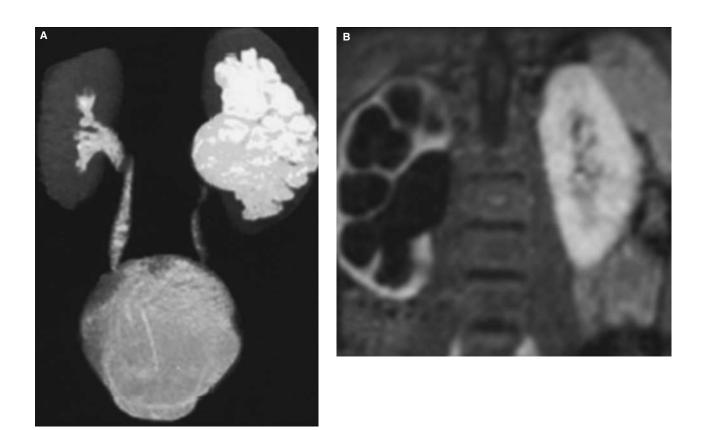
(A) Magnetic resonance imaging (MRI): maximum intensity projection reconstruction after Gd-DTPA infusion in a patient with left ureteropelvic junction (UPJ) obstruction. (B) Differential function determination in post-Gd-DTPA MRI in UPJ obstruction (R:L ratio 28:72). (Reproduced with permission from Perez-Brayfield et al.⁸²)
